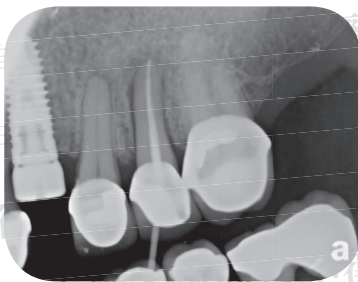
Periapical radiograph of tooth #25, an unrestorable fractured tooth, which was extracted in the following treatment sequence.
